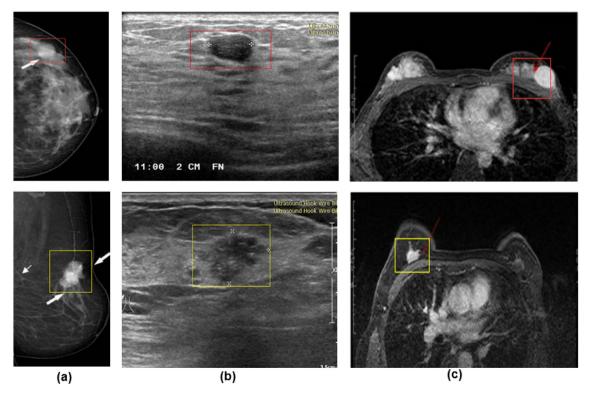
The samples of benign (top row) and malignant (bottom row) breast masses on mammography (a), ultrasound (b), and MRI (c).
